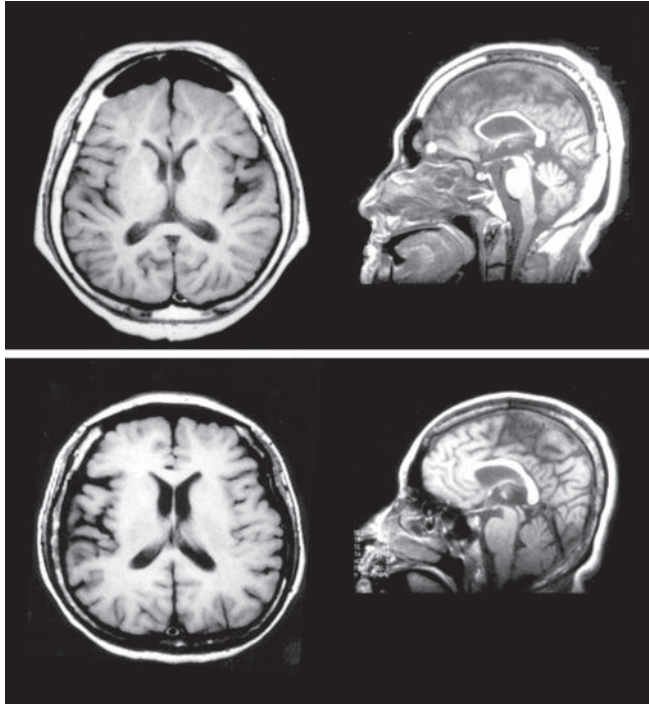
In Rett syndrome (RS), there is progressive reduction in white matter (throughout the brain) and in gray matter (most notably in the frontal and anterior temporal regions). The MR images in the top row are from a 46-year-old patient with RS. Visible pathological findings include narrowing of the corpus callosum, widening of the prepontine cistern, narrowing of the brain stem, cerebellar atrophy, frontal and temporal lobe atrophy, and dilation of the sylvian fissures. The images in the bottom row are from a 35-year-old female patient with RS. Similar pathology is visible, including dilation of the sylvian fissures and ventricle and atrophy of the frontal and temporal lobes. The cerebellum and brain stem also demonstrate some mild atrophy. From Gotoh et al. (2001). Copyright 2001 by Elsevier. Reprinted by permission.
